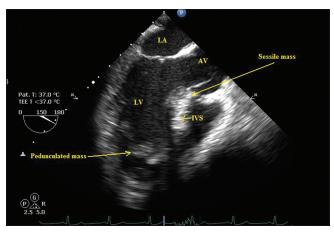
Midesophageal long axis view of tranesophageal echocardiography showing two left ventricular masses
